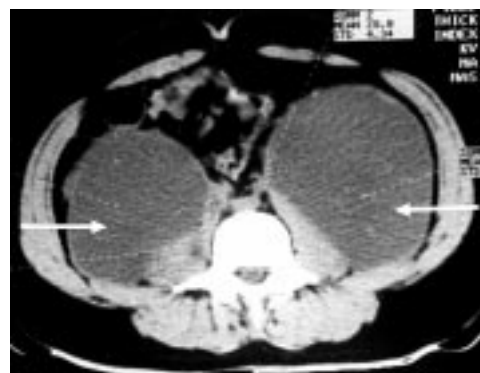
Computed tomography of the abdomen showing similar changes as in fig 1 but at a lower level.
